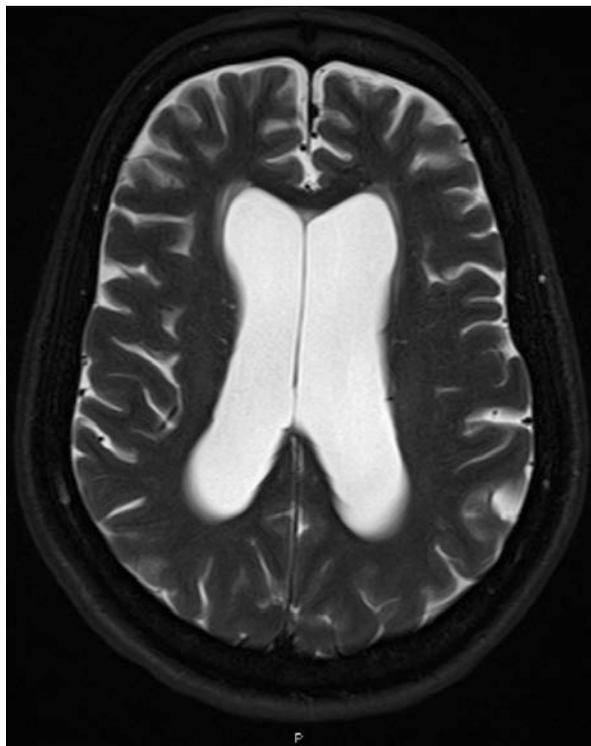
Ventriculomegaly on CT of the brain; finding typical for individuals with a diagnosis of NPH
